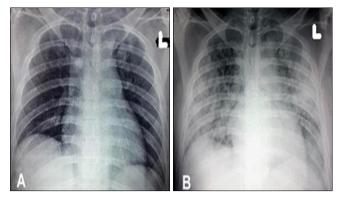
(A): Chest radiograph on admission was normal. (B) Chest radiograph on day 2 of admission showed bilateral diffuse air space opacities
